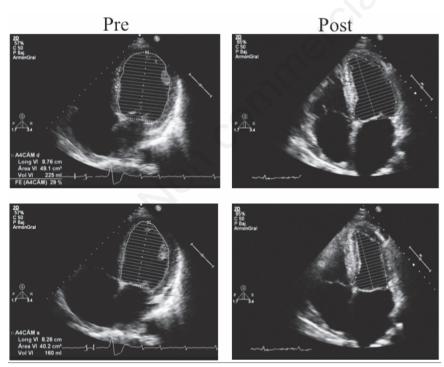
Echo still frame images (diastole top panels, systole bottom panels) from a 52year old male admitted for acute heart failure and past medical history including hypertension, atrial fibrillation and consumption of 100 g of alcohol per day for more than 20 years and normal coronary arteries. An echocardiogram (left panels) showed a very dilated left ventricle (LV), with LV ejection fraction <25% and right ventricular (RV) mild to moderate systolic dysfunction. An echocardiogram performed 6 years after first evaluation (right panels), after standard heart failure medication and complete alcohol intake withdrawal, shows normal LV and RV size and function.
